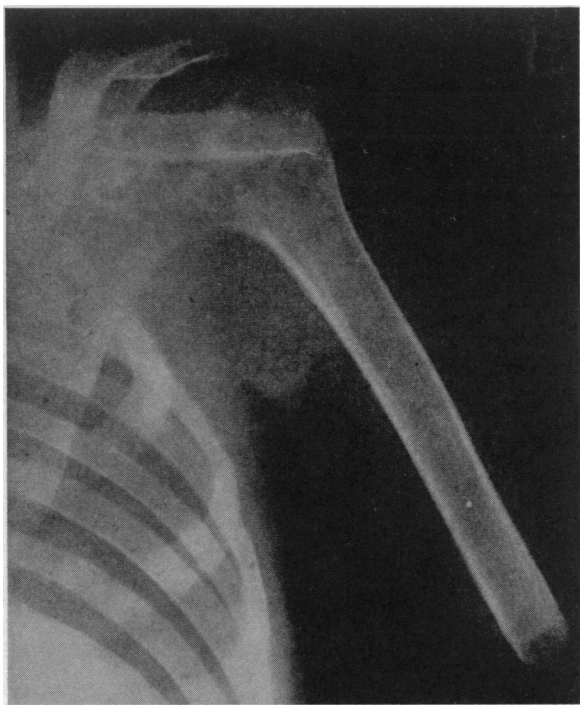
X-ray photograph of this case.
